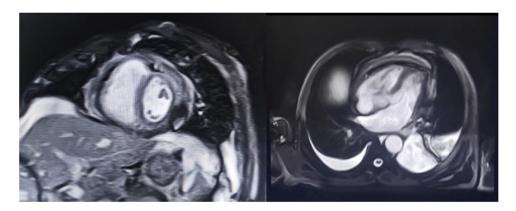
Cardiac MRI shows pericardial thickening and calcifications mostly adjacent to the right ventricle.
